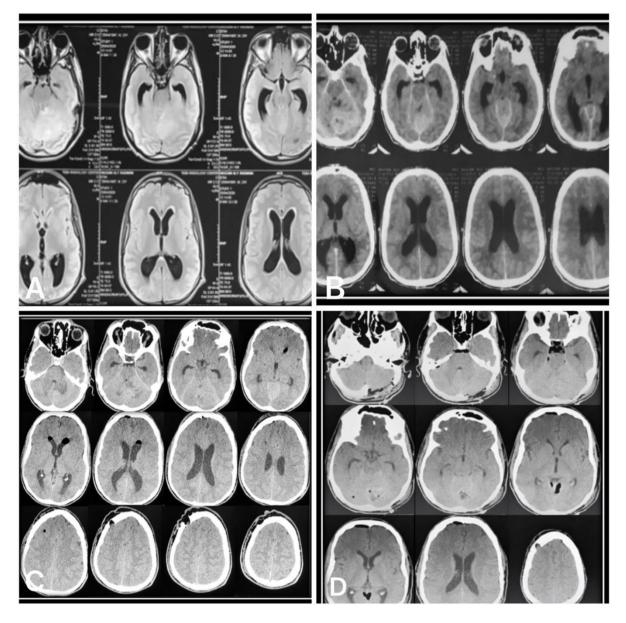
Preoperative MRI brain shows a posterior fossa mass and hydrocephalus, CT of the same patient, early postoperative CT shows good resolution of hydrocephalus after ETV prior to tumor excision surgery, CT after tumor excision shows complete resolution of hydrocephalus.
